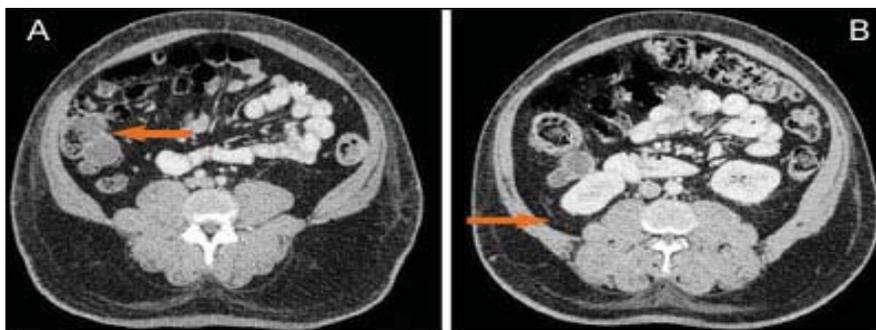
CT scans showing a well-defined, fluid-filled mass (arrows) arising from the cecum in the right mid-abdomen and abutting the terminal ileum (A and B).
